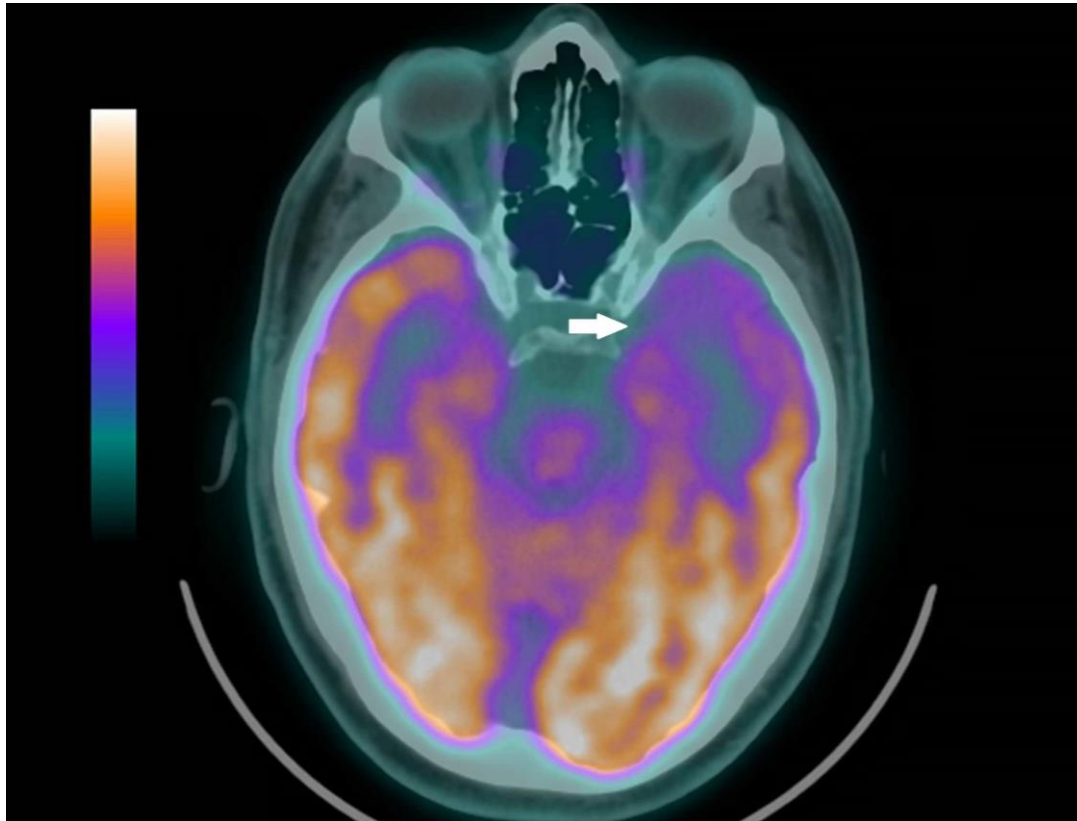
FDG-PET demonstrates hypometabolism (white arrow) in a man with a normal MRI brain in the left temporal lobe. He became seizure-free following a left anterior temporal lobectomy.
